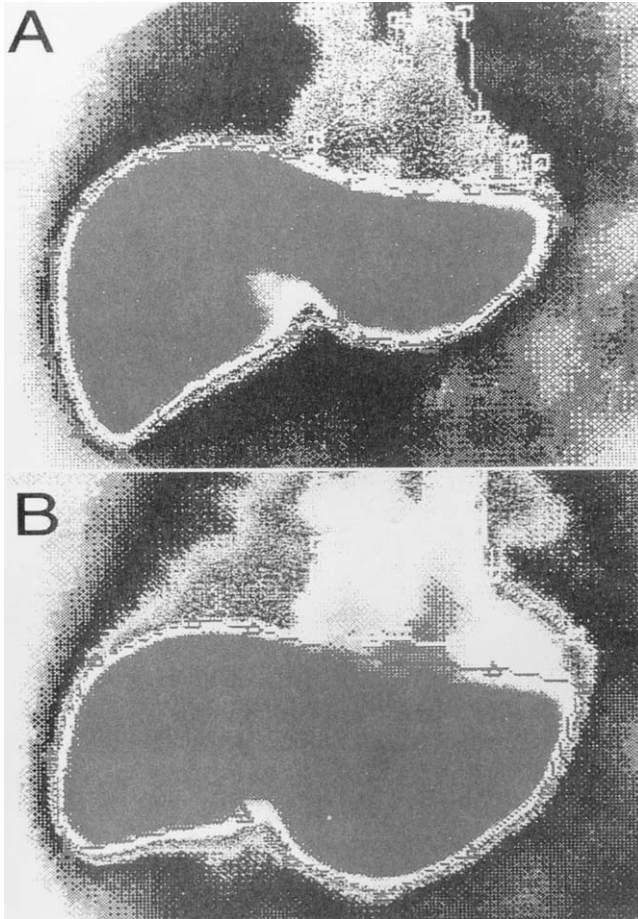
GSA planar image before and after right portal vein embolization demonstrating both the increased left lobes size and asialoglycoprotein receptor number. SPECT images are also obtainable. (From Kubo S, Shiomi S, Tanaka H, Shuto T, Takemura S, Mikami S, Uenishi T, et al. Evaluation of the effect of portal vein embolization on liver function by  $^{99m}\text{Tc}$ -galactosyl human serum albumin scintigraphy. *J Surg Res* 2002;107:113–8; p. 132; with permission.)
